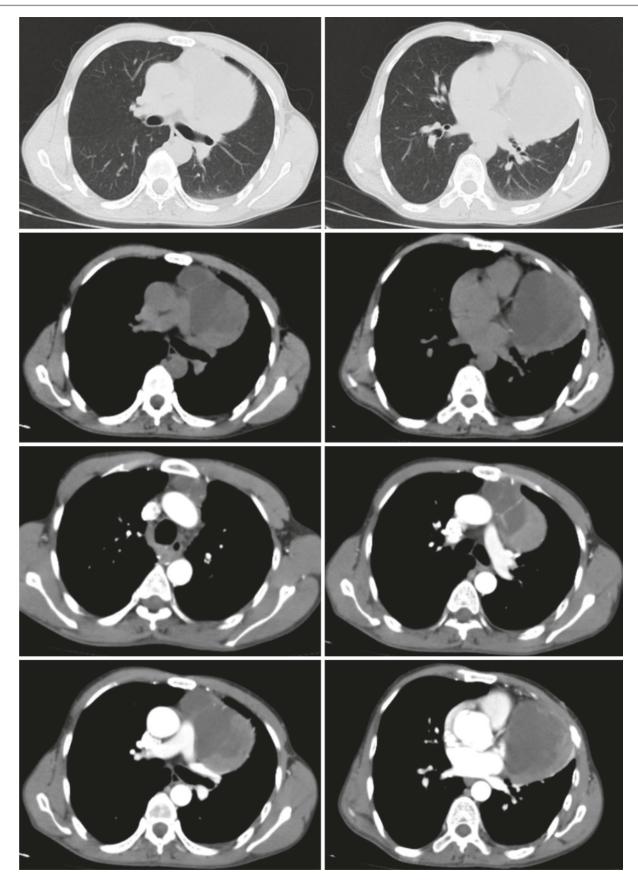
Chest CT images of a 42-year-old man found a mediastinum mass for 20 days
